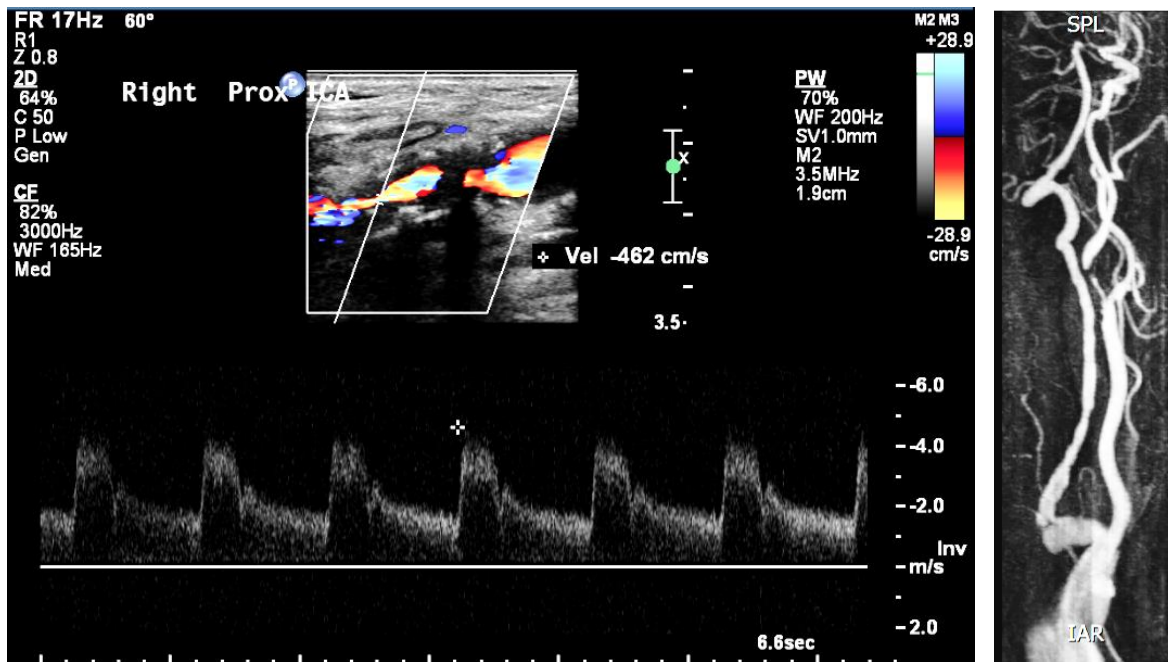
Carotid Duplex Ultrasound exam of right carotid bifurcation (left) together with MR angiogram image (right) both showing a tight ICA stenosis.
